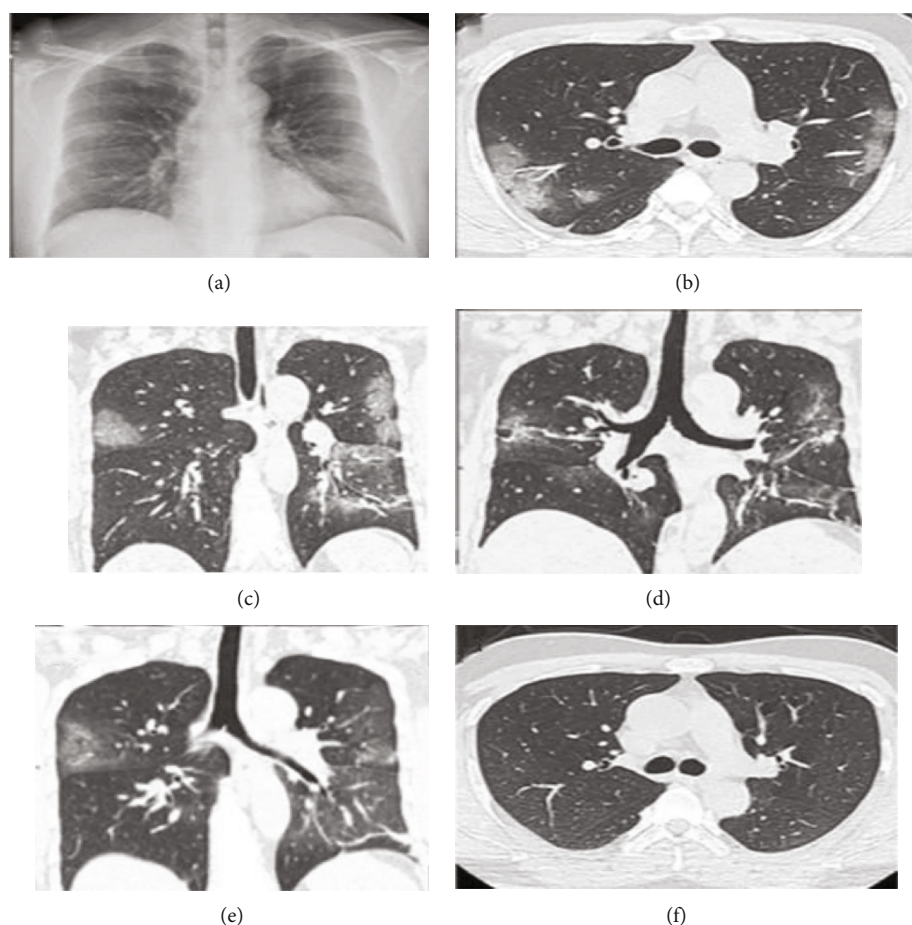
CT scan images of a COVID-19 patient as time goes by. (a) 7th Day (as soon as symptoms show up): CT scan presents opacities formed in left lower lobe and right upper lobe. (b, c) 9th Day: CT scan depicts ground-glass opacities which are bilateral and multifocal. (d) 15th Day: CT scan presents that virus has evolved into mixture of consolidations and opacities. (e) 19th Day: CT scan shows partial disappearance of ground-glass opacities and consolidations using antiviral treatments. (f) 31st Day: CT scan shows absence of pleural effusions, pulmonary cavitation, and lymphadenopathy [2–4].
